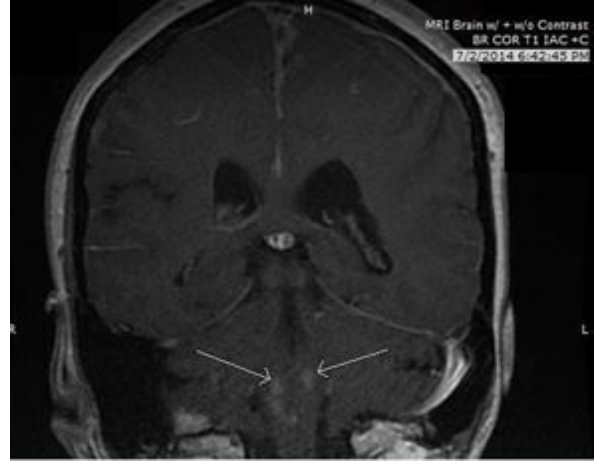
Coronal T1W MRI demonstrates small foci of abnormal hyperintense signal demonstrated within the dorsal medulla (arrows).
